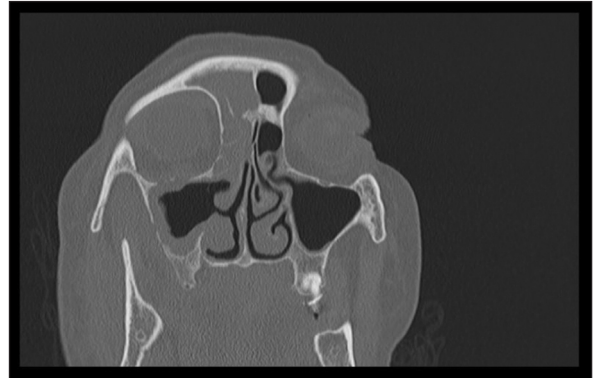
Computed tomography image before 2nd surgery.
